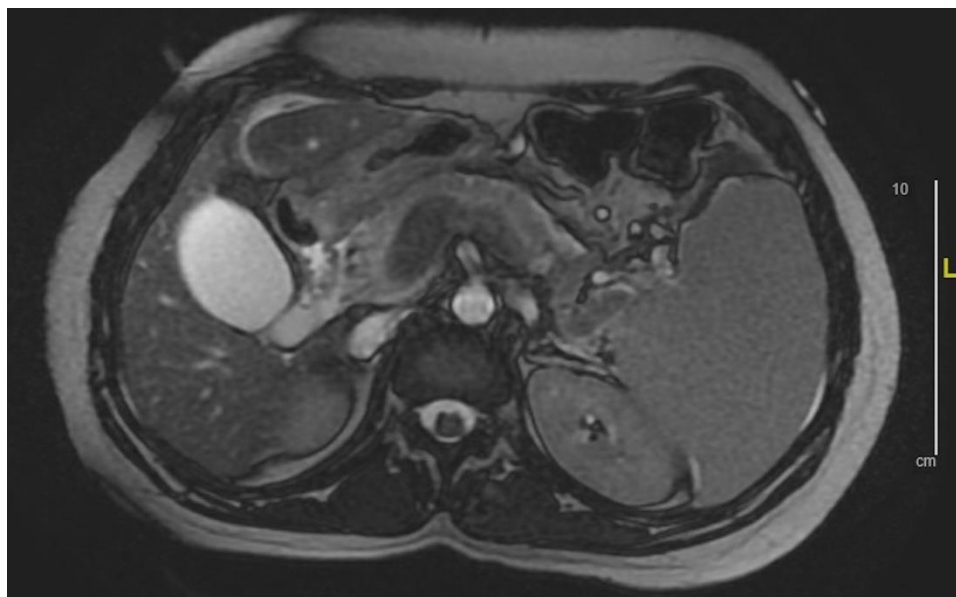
Axial MRI image showing complete thrombosis of the main and intrahepatic portions of the portal vein with thrombus extending retrograde into the distal superior mesenteric vein and into the distal and midportions of the splenic vein. There are perisplenic varices and splenomegaly compatible with portal hypertension.
